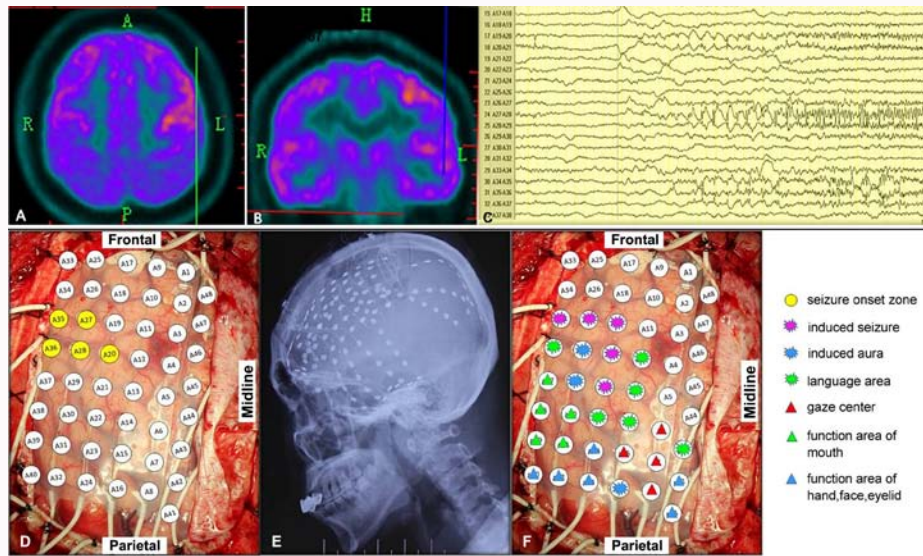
A 12-year-old male with interictal Positron Emission Tomography (PET) hypermetabolism in the left frontal lobe (patient 5). PET imaging (A, axial; B, coronal) showed moderate hypermetabolism in the posterior middle and inferior frontal gyrus of left frontal lobe. Ictal iEEG monitoring (C) demonstrated a very focal seizure onset zone, which was concordant with the PET hypermetabolism zone (sites A20, A27–28, and A35–36). Subdural grids (D), yellow sites represent the seizure onset zone, X-ray film (E), to determine the position of the electrodes, and the result of electrical cortical stimulation (ECS) foci (F), the area with ECS-induced auras and seizures overlapped with the seizure onset zone, and was also adjacent to the Broca area.
